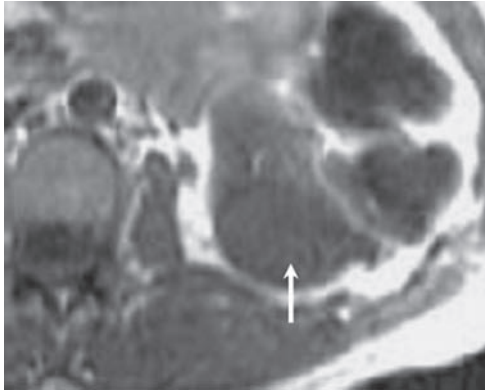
Coronal T1-weighted image with fat saturation following Gadolinium enhancement. The chromophobe RCC is a solid homogenous mass with spoke wheel enhancement again mimicking an oncocytoma.
